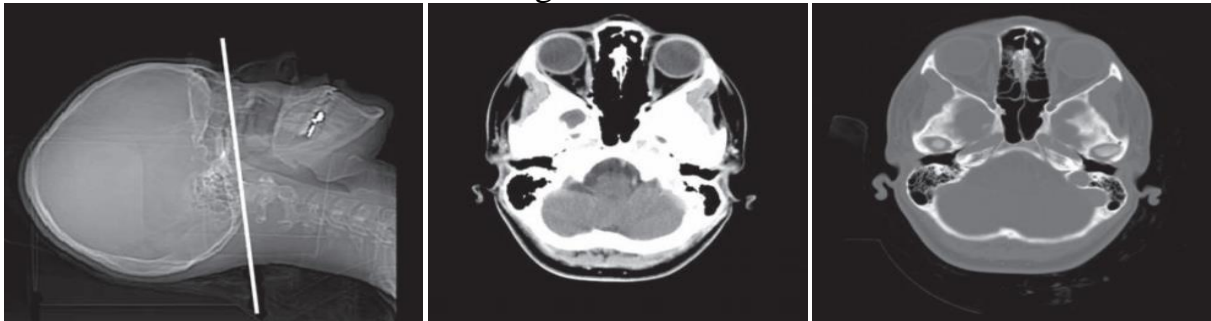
shows the axial CT scan
